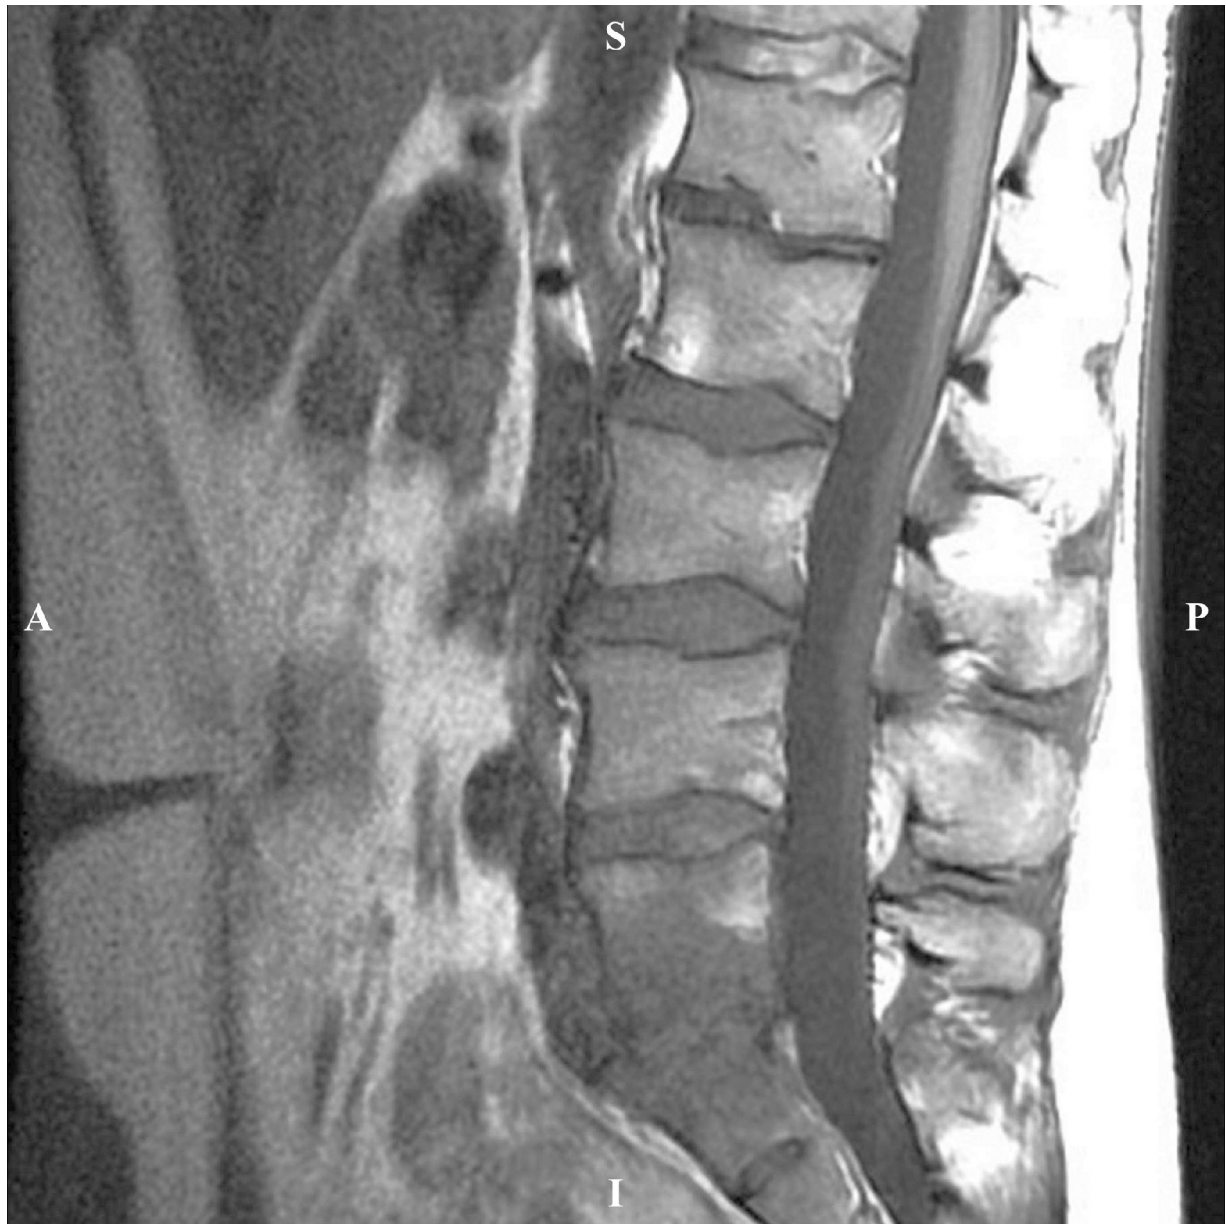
Case 1: Non-contrasted pre-op MRI showed marked disc degeneration and adjacent vertebral body inflammation at L5-S1, consistent with discitis.
